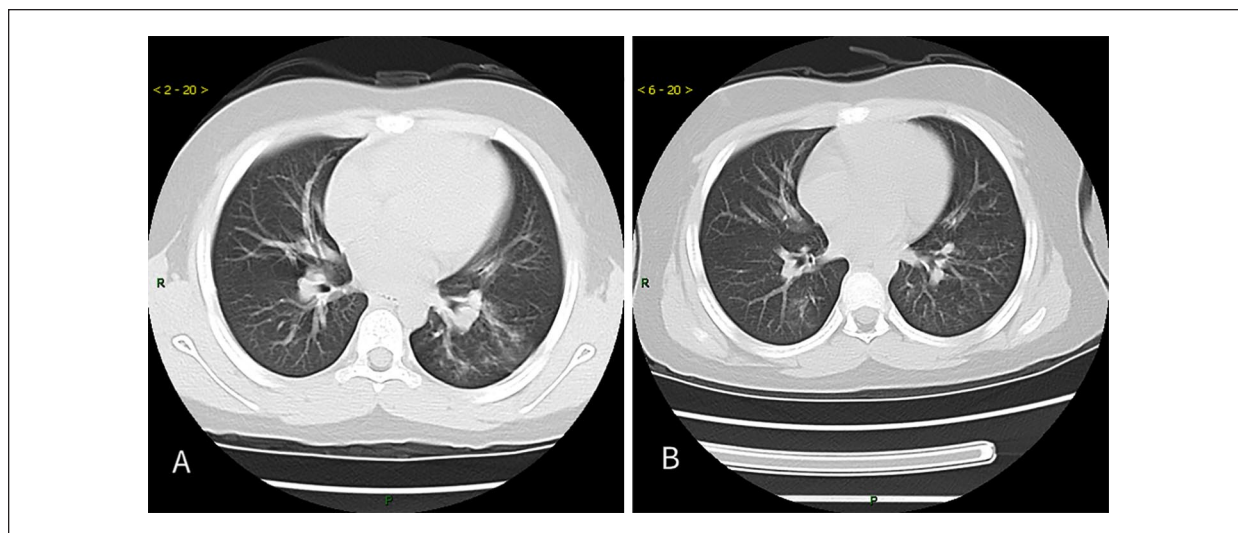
(A) The computed tomography (CT) scan of chest revealed bilateral lung infection and consolidation in part of the lower lobe of the left lung. (B) The repeat chest CT scan showed that the lung infection was basically absorbed.
